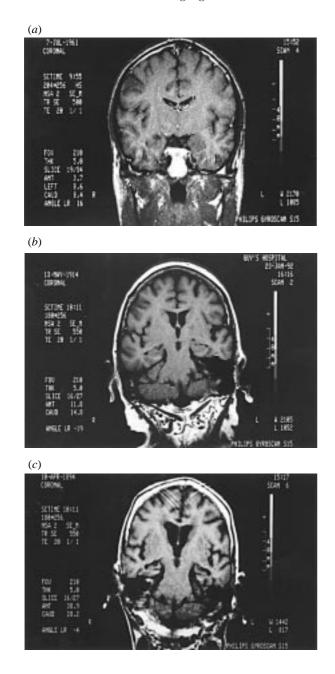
Magnetic resonance images of healthy and Alzheimer's disease human brains. Coronal MRI scans of the brains of (a) a healthy 35-year-old male; (b) a healthy 82-year-old female; (c) a 99-year-old female with Alzheimer's disease.
